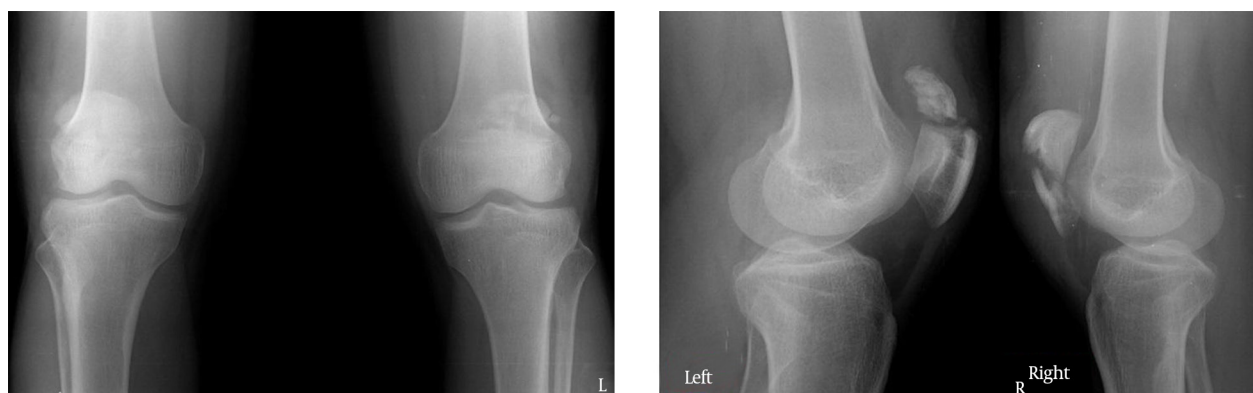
Pre-Operative X-rays (Antero-Posterior and Lateral Views) Both Knees
